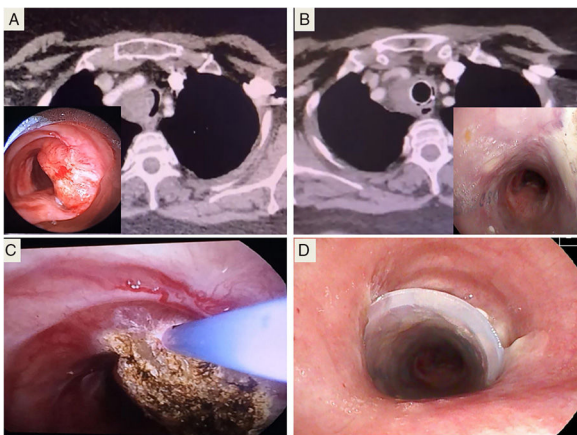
(A) Bronchoscopy and CT image of tracheal stenosis. (B) Outcome after treatment with corticosteroids and stenting, after 4 months. (C) Argon plasma coagulation, after biopsy. (D) Placement of Dumon[®] stent.
